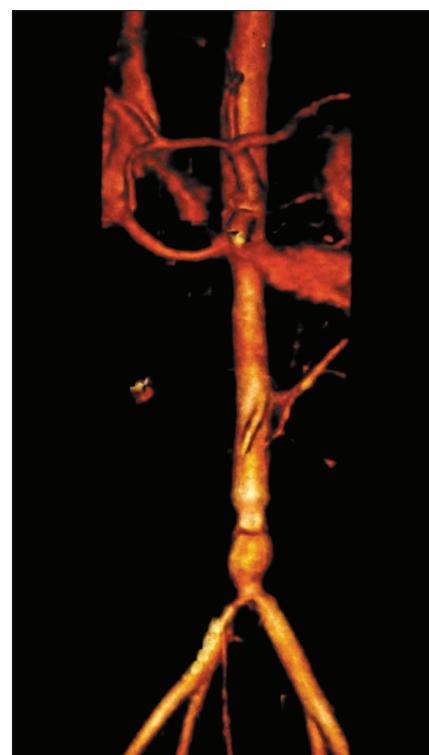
CT angiography showing transection of the distal abdominal aorta and right common iliac artery.
